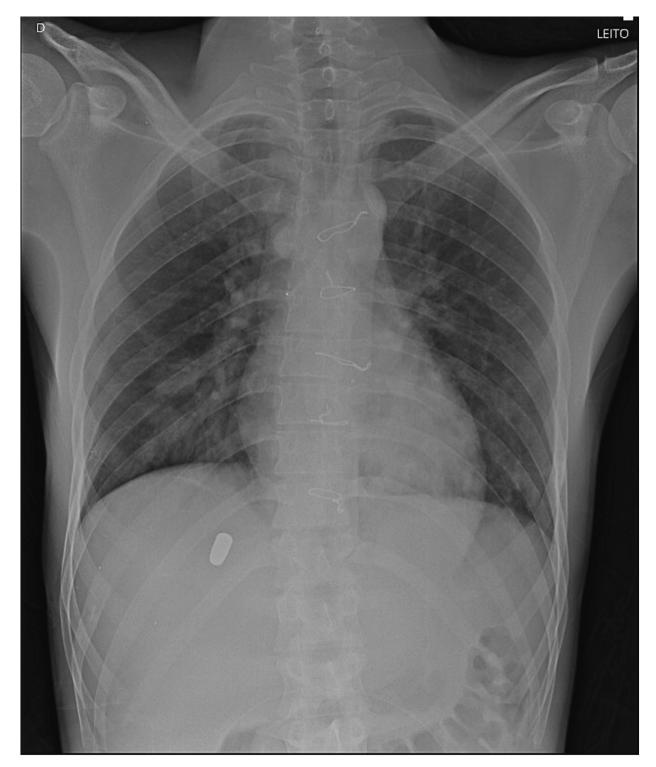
X-ray executed three years after the trauma showing the location of the projectile in the liver position.
